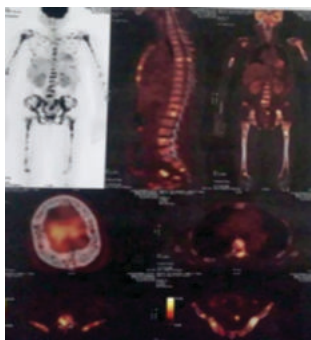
PET-CT shows multiple metabolically active lytic lesions.
